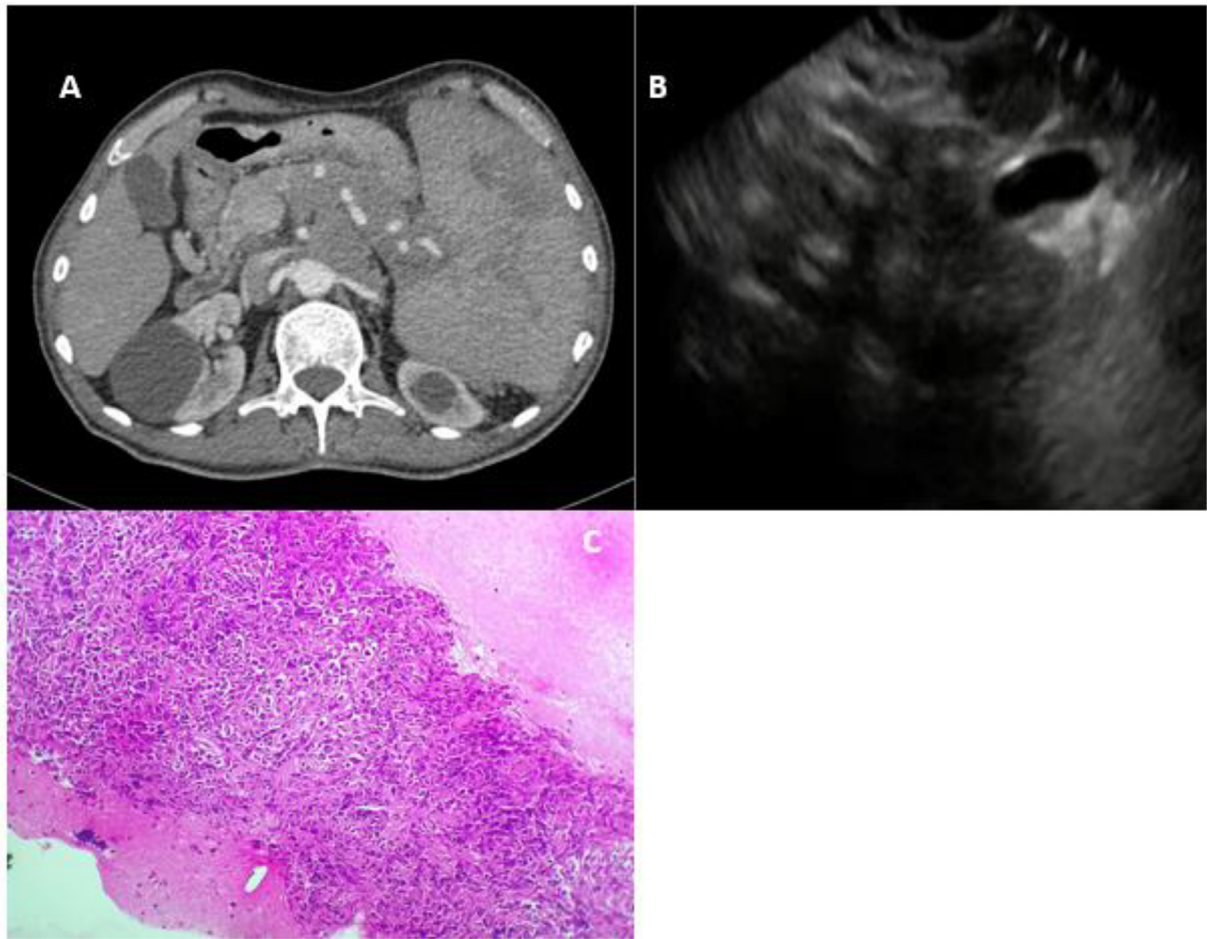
Case 3. (A) Abdominal CT scans showed an infiltrated and hypodense lesions in the body and tail of the pancreas. (B) EUS image of the third clinical case showing an irregular mass occupying the body and tail of the pancreas. (C) The cytological results of the FNA of the third case confirming the diagnosis of a diffuse large cell B lymphoma.
